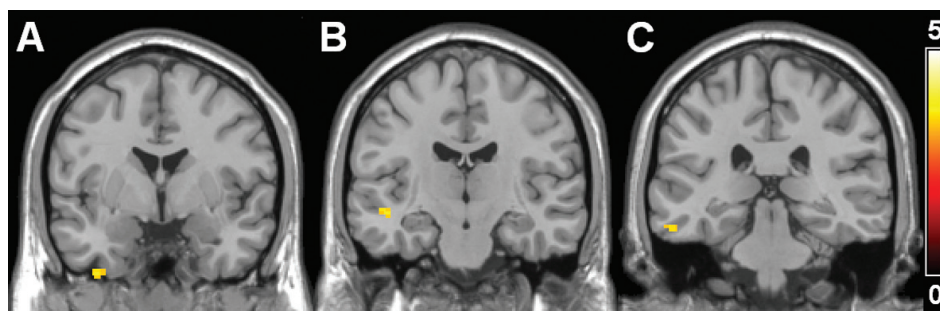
Statistical parametric maps demonstrating increases in DSC-MRI measured cerebral blood volume (CBV) in MO patients compared to headache-free control subjects in the inferior temporal gyrus (A,C) and middle temporal gyrus (B), superimposed on a T_1 -weighted template in MNI standard space. Colour bars represent Z-values. The left side of each picture is the right side of the brain.
